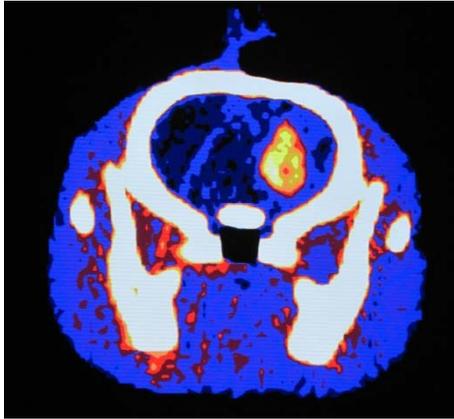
An example CT-image, demonstrating the high TI-uptake in the tumour.
